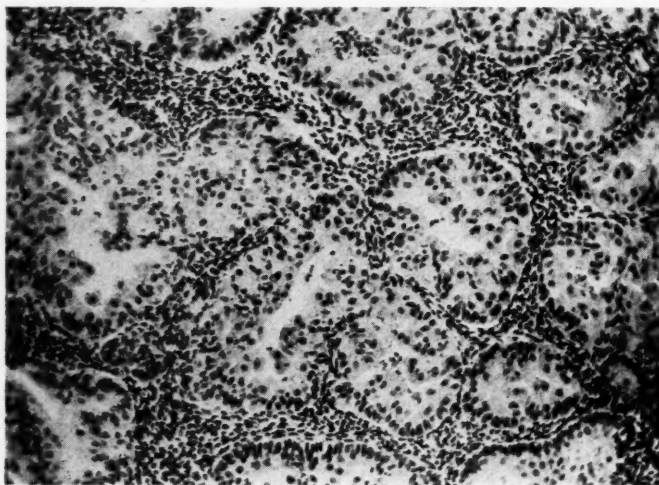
Glandular hyperplasia with intense epithelial proliferation. The 43-year-old patient has been under observation for 19 months. Eleven months ago x-ray castration; since that time no bleeding. ( $\times 170$ .)
